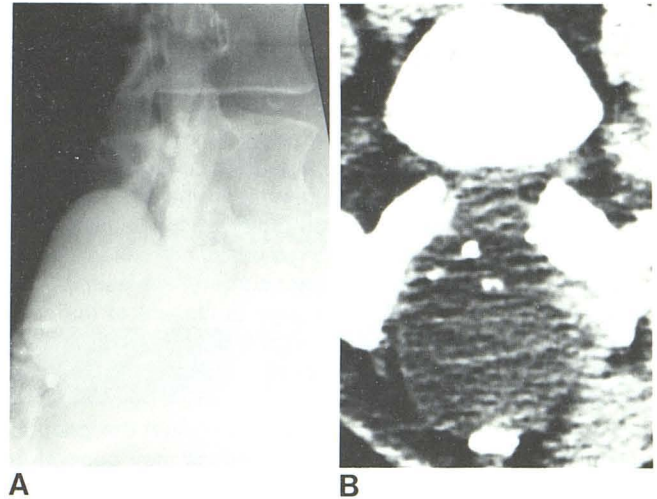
Communicating lumbar postlaminectomy pseudomeningocele. Multiple previous operations were performed on lumbar spine, including attempted repair of CSF leak from dural tear 2 years before these examinations. The patient had low back pain radiating to the right leg and headaches induced by bending or straining, which were relieved by recumbency. A, Lateral view from lumbar metrizamide myelogram. Large pseudomeningocele is filled with metrizamide and residual Pantopaque. B, CT 4 days after myelography. No definite separation of lesion from thecal sac is delineated. Interval since myelography accounts for lack of metrizamide in lesion. Lesion was 4½ × 5½ cm.
